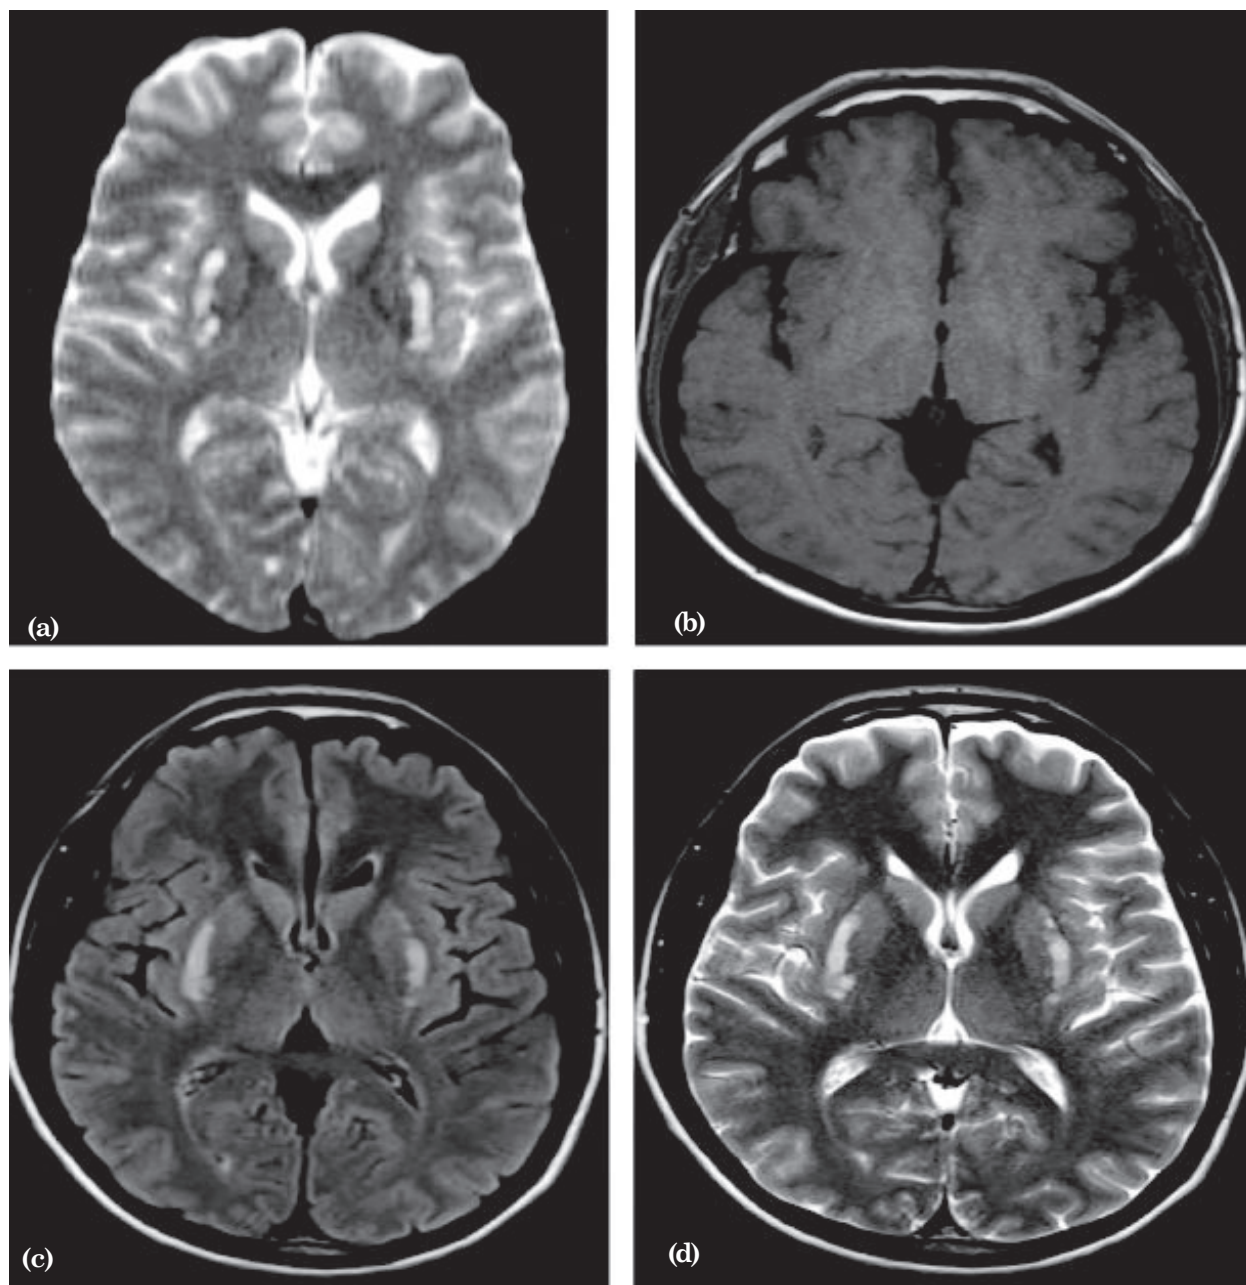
a, b, c & d: Axial ADC, T1, FLAIR & T2W images showing bilateral necrosis of putamen.
